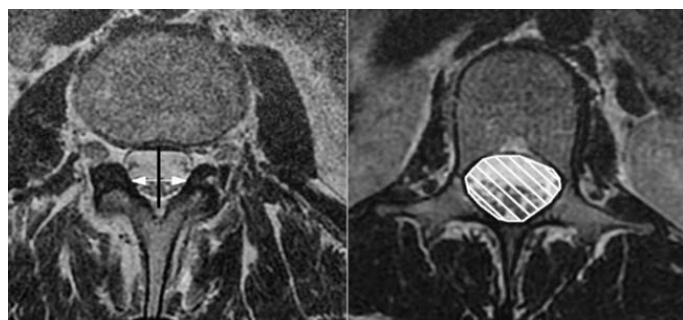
Lumbar central spinal canal dimensions on MRI scans.
